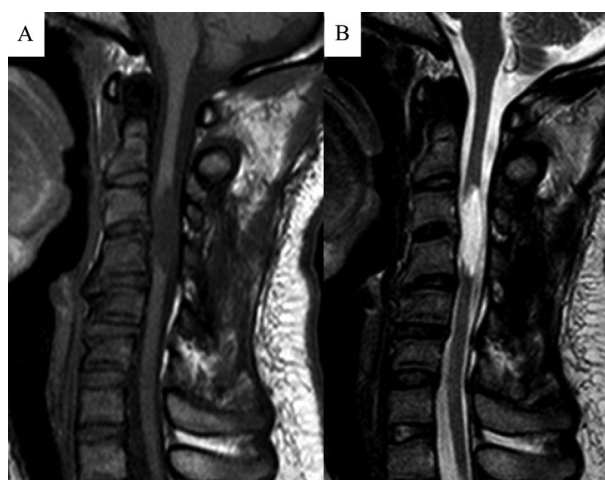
Mid-sagittal T1-weighted (A) and T2-weighted (B) MR images 4 years after surgery. The MR images show the signal changes in the spinal cord at the C3/4 level.
